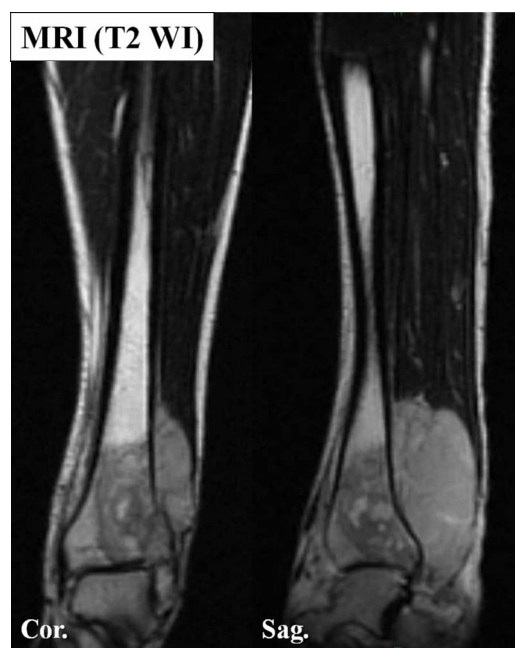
MRI showing osteosarcoma at the left distal tibia.
